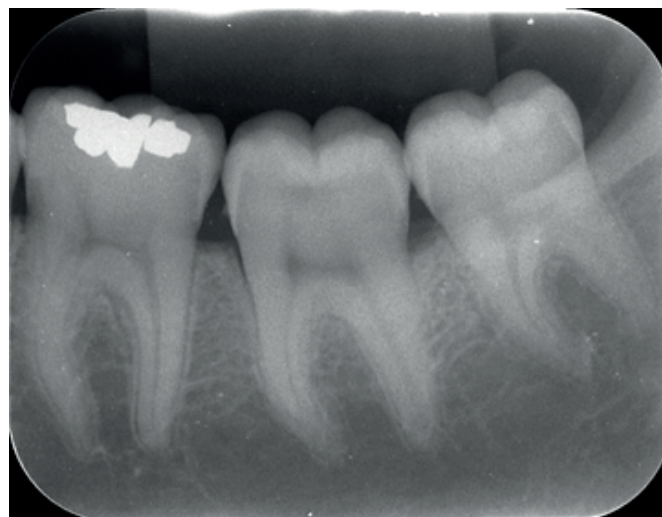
Periapical radiographic image.
